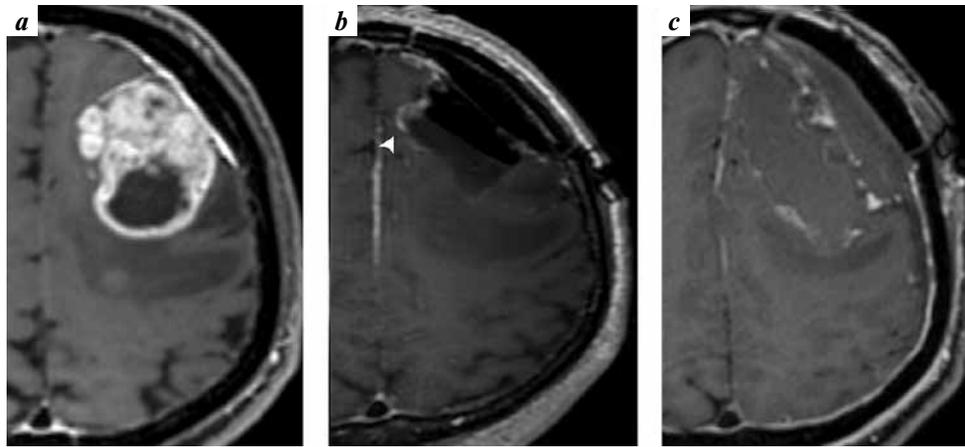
Brain MRI (Patient no. 3). Axial T1 contrast-enhanced images: a – preoperative MRI, high-grade frontal lobe tumor; b – intraoperative scan, residual tumor (arrowhead); c – postoperative MRI, no signs of tumor after additional resection
